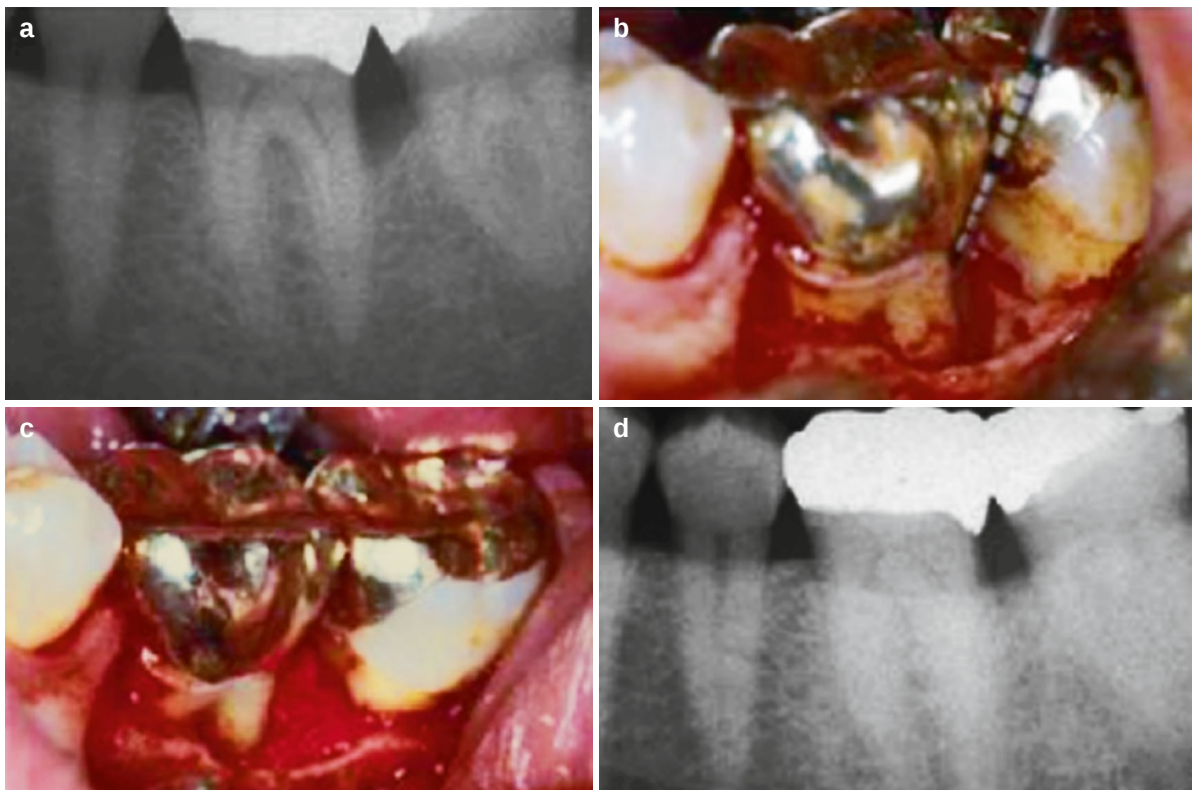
Pretreatment, surgical procedure, and week 24 radiographs of a defect treated with the local delivery of 0.3 mg/mL of rhPDGF and β -tricalcium phosphate. (a) Pretreatment radiograph shows bony defect on the mesial of tooth #18. (b) After flap reflection and degranulation, an infrabony defect of 6 mm is
